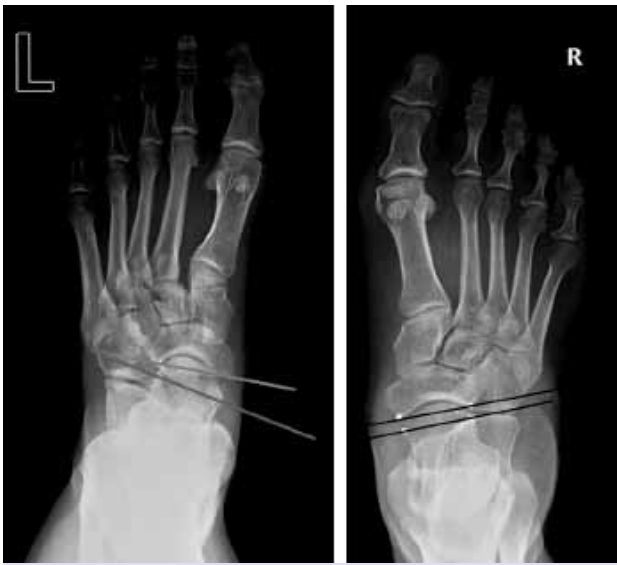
Normal, and deformed talonavicular grasping angle. On dorsolateral radiographs obtained while the patient is standing on foot, the angle formed by the bisection of the antero-medial, and the anterior-lateral extremes of the talar head, and the bisection of the proximal articular surface of the navicular. If it is more than 7 degrees, then it indicates presence of a lateral talar subluxation.
